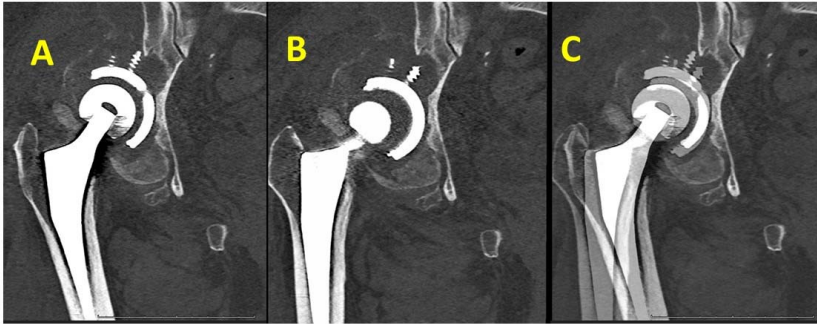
CT IMA of an obviously loose acetabular component for descriptive purposes. A) Acetabular position during the first stress pose. B) Acetabular position during the second stress pose. C) Overlaid images of the two stress poses showing the gross movement of the acetabular position.
